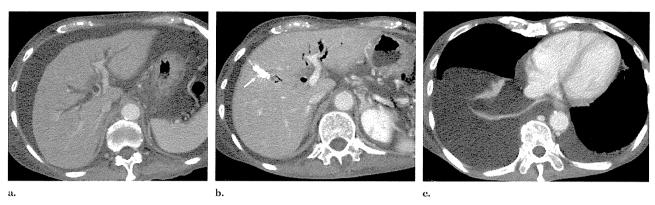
Gastric cancer with nodal metastasis in a 57-year-old man (patient 5). (a) Contrast-enhanced CT before the procedure shows dilated intrahepatic biliary ducts and massive ascites. (b) Contrast-enhanced CT after the procedure revealed improvement of obstructive jaundice and decreased ascitic fluid. Note that the transhepatic tract was tightly packed with metallic coils (arrow). (c) Contrast-enhanced CT also showed significantly increased right pleural effusion.
